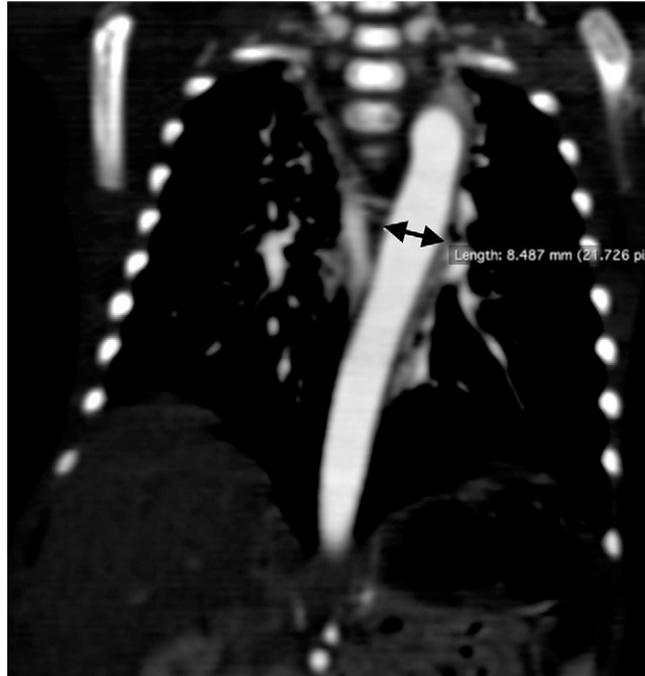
Contrast CT angiogram of the thorax reveals a dilated thoracic aorta (arrow) before vitamin A therapy.
